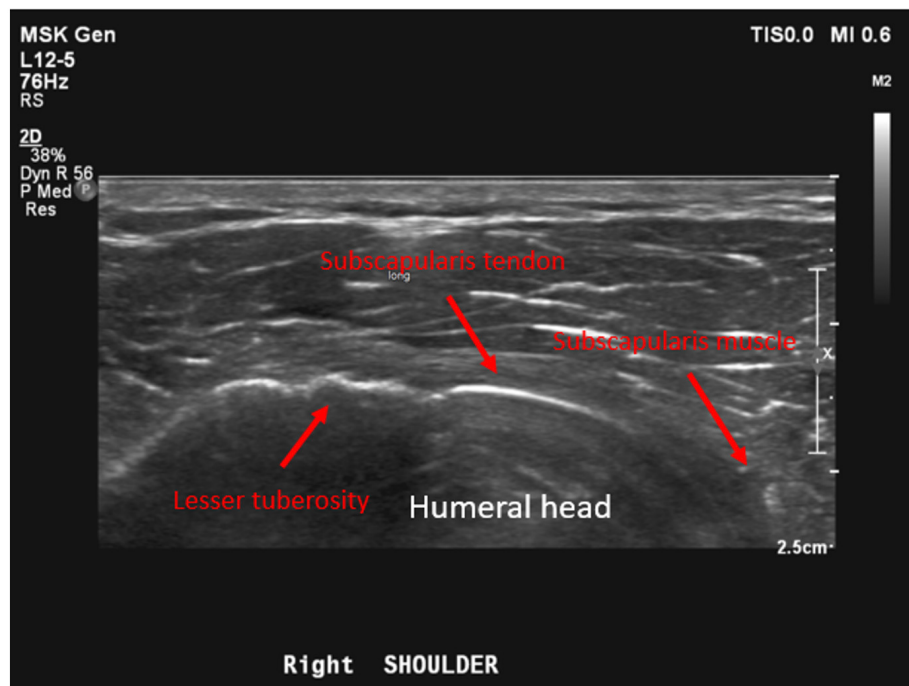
Patient #5 representative 6-month post-operative ultrasound showing intact subscapularis tendon with normal fibrillar echogenic tendon architecture and no evidence of tendinosis or tear.
